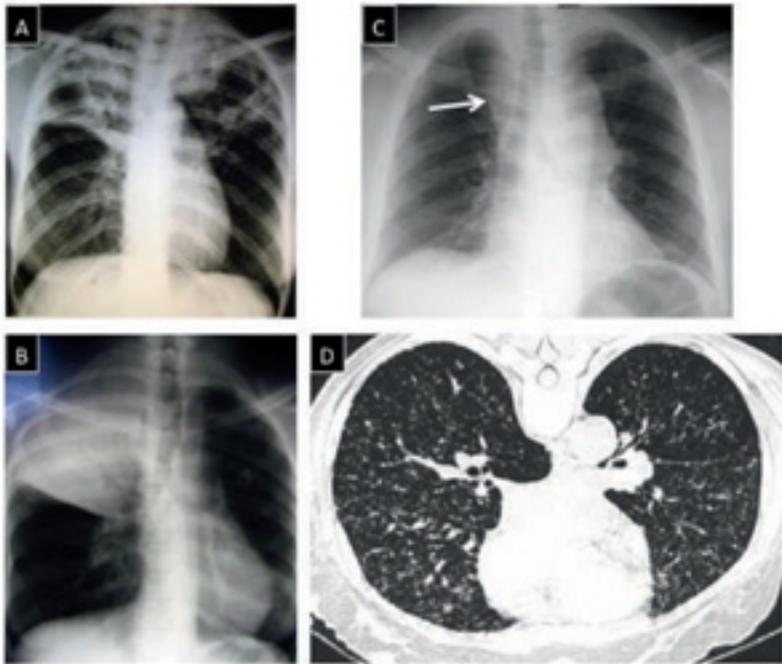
Cavitory bilateral upper-lobe consolidation (A); right upper-lobe consolidation with air bronchogram (B); right para-tracheal lymphadenopathy with normal lung parenchyma (C); miliary TB pattern on CT scan (D).
